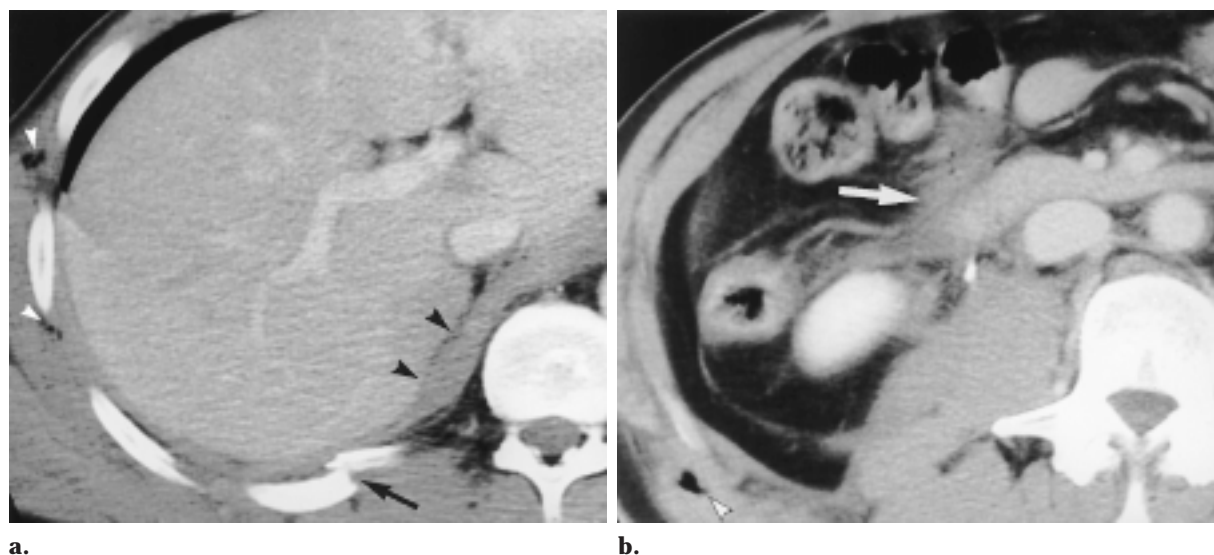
Right diaphragmatic rupture and duodenal contusion in a 43-year-old man. (a) Abdominal CT scan shows a posterior right rib fracture (arrow) at the site of a diaphragmatic hematoma (black arrowheads). (b) On a CT scan obtained at a lower level, extension of the diaphragmatic hematoma into the posterior pararenal space (arrow) was erroneously thought to be the source of the periduodenal hematoma in the anterior pararenal space. Subcutaneous air (white arrowheads in a and b) from barotrauma is visible.
